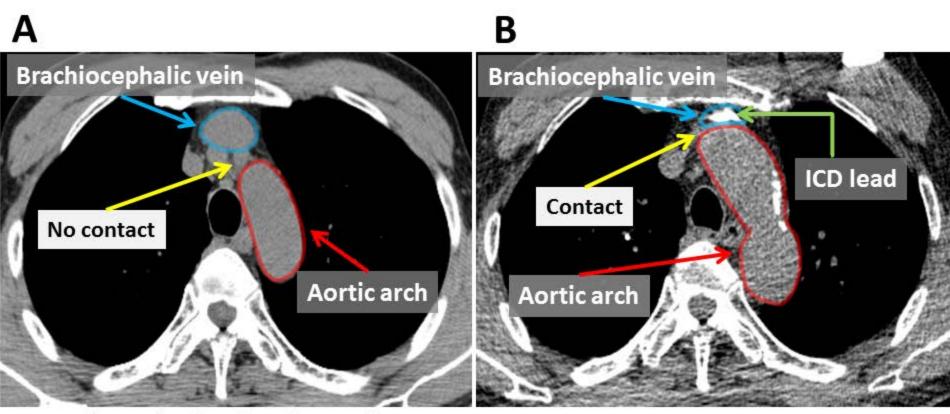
Chest CT before and after device implantation
